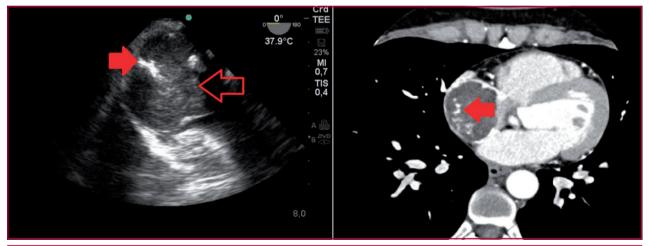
Transesophageal echocardiography and computed tomography show a myxoma of the right atrium. Filled arrow indicates calcifications within the tumor. Hollow arrow indicates atrial wall.
